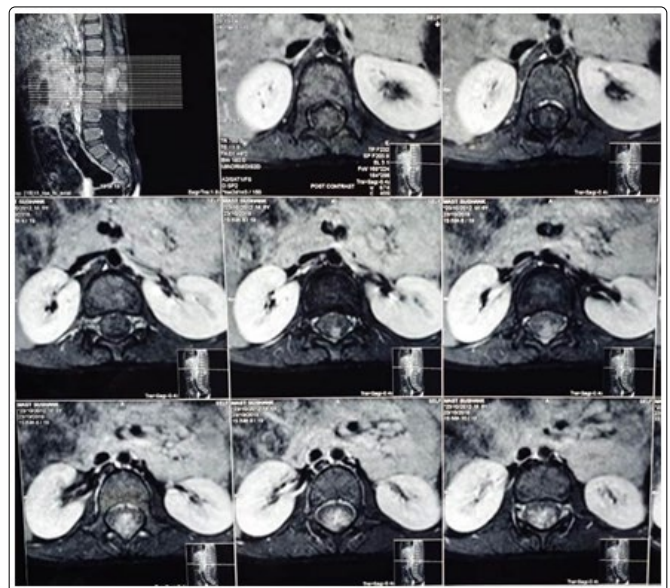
T1 MRI contrast axial sections showing a lesion with heterogenous enhancement involving conus-cauda region IDEM
